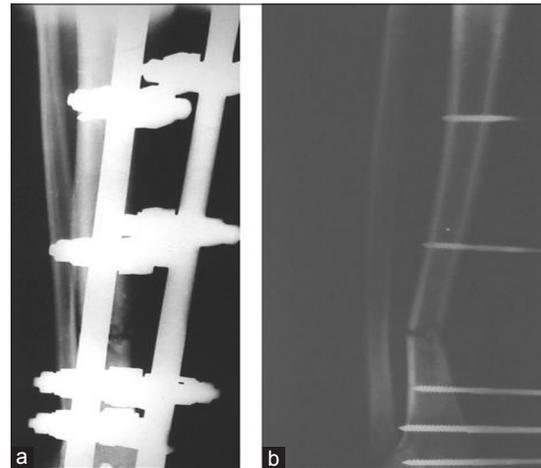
(a and b) Tibia pre-operative X-ray, compound Grade III B with flap cover
